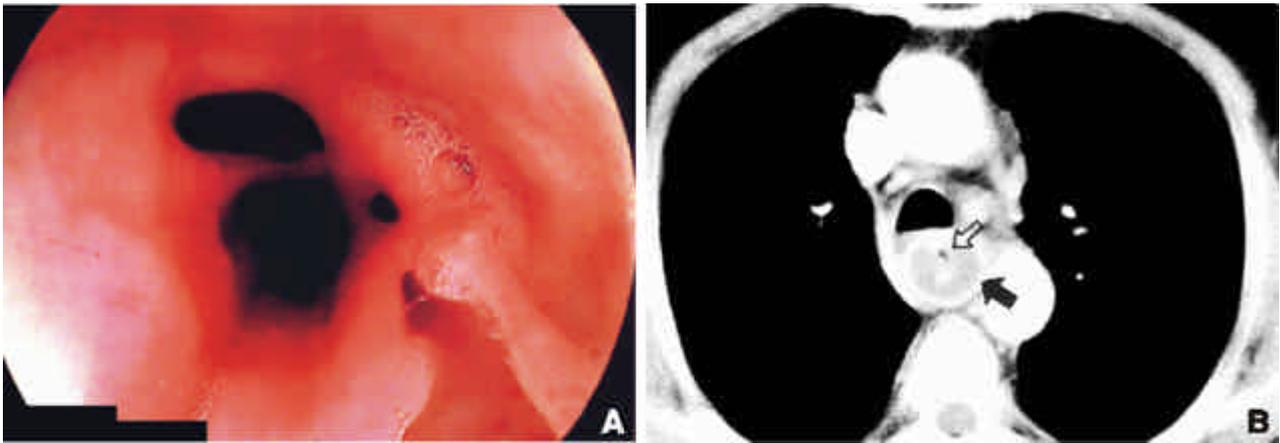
A 68-year-old man with aggravating swallowing difficulty after endoscopy. Initial studies. A: Endoscopic examination shows multiple and irregular mucosal defects communicating with another lumen. B: Initial CT scan at the level of aorticopulmonary window shows two lumens of the esophagus. Air-filled smaller inner lumen (open arrow) is surrounded by hematoma-filled larger outer lumen (closed arrow). A thin enhancing rim of the esophagus suggests mucosal lining.
